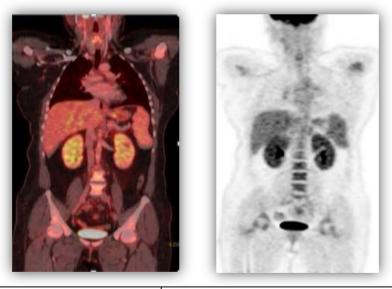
Post treatment whole body MIP PETFig. 6d: Post-treatment whole body coronal PET/CT fusedimageimage
